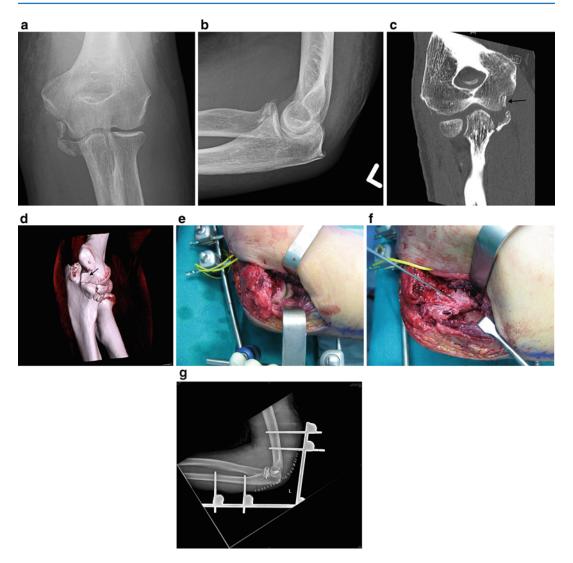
Anteroposterior and lateral radiographs demonstrate a severely comminuted anteromedial coronoid fracture (\mathbf{a} , \mathbf{b}). Coronal CT (\mathbf{c}) and 3D reconstructions (\mathbf{d}) demonstrate the degree of comminution and the extruded osteochondral fragment (*black arrow*). Due to the degree of comminution, the patient underwent open reduction
